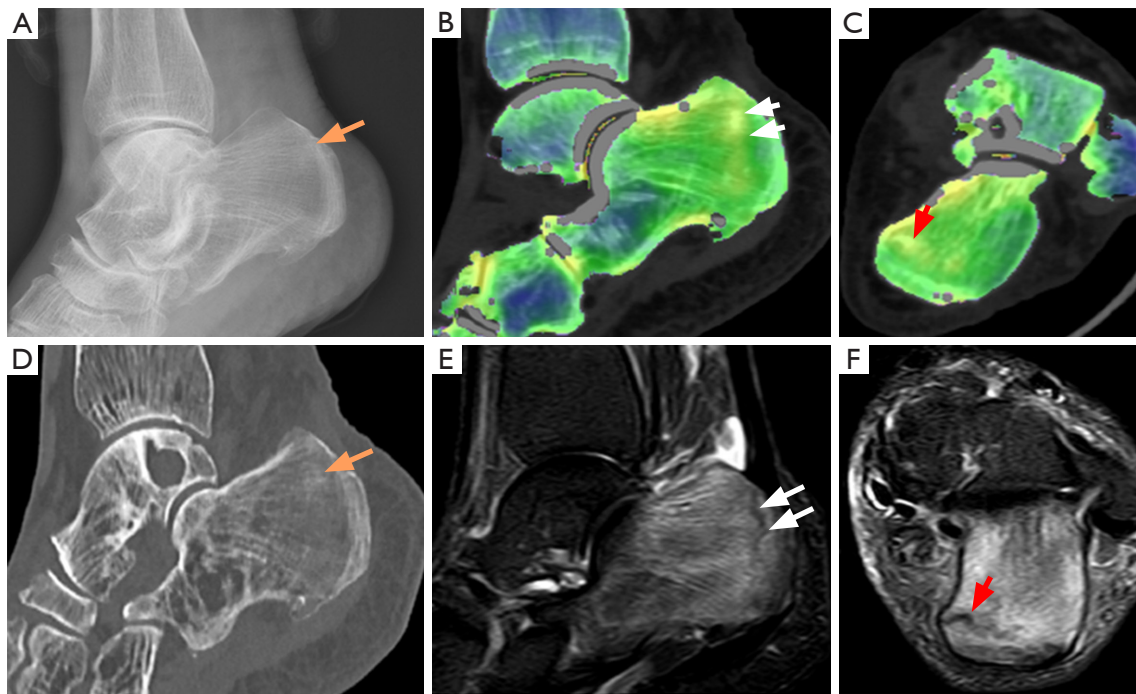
Images of a 64-year-old female with clinical suspicion of calcaneus fracture after trauma with negative findings on radiographs. X-ray radiography, MRI, and DECT scans were performed at 2, 6, and 7 h after the trauma, respectively. (A) No positive findings were observed on the X-ray radiograph (orange arrow). (B) Sagittal reformation of the DECT color-coded VNCA image of the left calcaneus showed a green area of BME and a yellow strip (white double arrows) of fracture. (C) Axial reformation of the DECT color-coded VNCA image of the left calcaneus showed a green area of BME and a yellow strip (red arrow) of fracture. (D) Conventional grayscale CT (Br59) showed the trabecular bone was slightly blurred (orange arrow), but no significant fracture line was observed. (E) Sagittal fat-suppression weighted imaging MRI scan of the left calcaneus showed significant BME and a clear fracture line (white double arrows). (F) Axial fat-suppression weighted imaging MRI scan of the left calcaneus showed significant BME and a clear fracture line (red arrow). MRI, magnetic resonance imaging; DECT, dual-energy computed tomography; VNCA, virtual non-calcium; BME, bone marrow edema; CT, computed tomography; Br, bone reconstruction algorithm.
